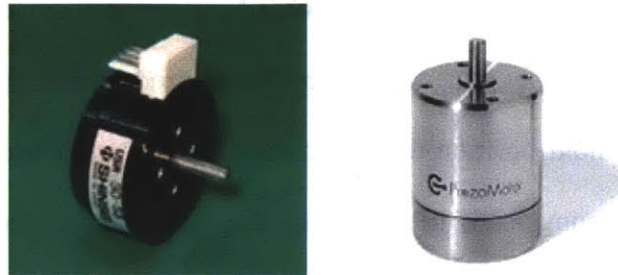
Non-magnetic actuators. Left: Shinsei ultrasonic motor. Right: LEGS rotatory piezoelectric motor.
